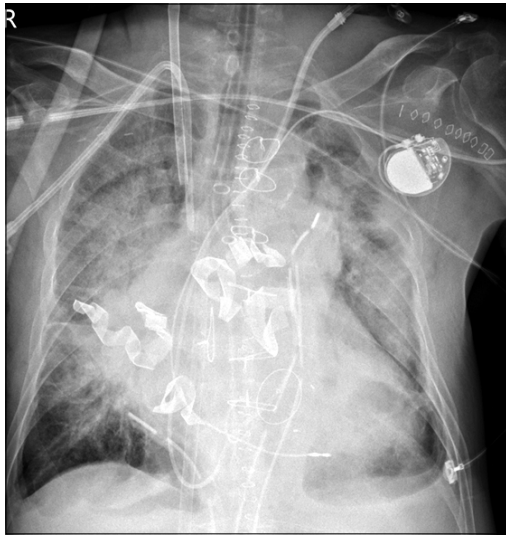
Immediate postoperative chest radiograph. Venovenous-type extracorporeal membrane oxygenation was applied due to respiratory failure attributable to severe lung laceration and massive hemorrhage.
